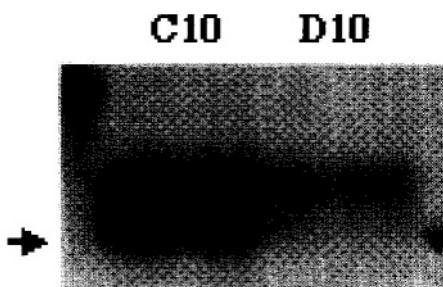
Expression of the FUS/CHOP fusion gene as determined by differential display of A375M melanoma. Cells were cultured in complete medium (C10) or in Tyr/Phe-deprived medium (D10) for 48 hr. The cells were harvested and total RNA was extracted with Trizol reagent (GIBCO-BRL, Grand Island, NY), according to the manufacturer's instruction. Three primers, (dT)12G, (dT)12C, and (dT)12A, were used to synthesize the first strand of cDNA with M-MLV reverse transcriptase (Promega, Madison, WI). The cDNA was used as a template to run PCR with arbitrary primers (Operon, Alameda, CA). [ $\alpha$ -<sup>33</sup>P]-dATP was used in the PCR reaction and the PCR products were fractionated on a urea-denatured 4.5% PAGE sequencing gel. The gel was dried in a Bio-Rad gel drier at 80 °C for 2 hr, exposed to X-ray film, and subsequently developed. The FUS/CHOP fusion gene band, indicated by the arrow in Figure 4, was cloned into the pGEM-T easy vector system (Promega). Specific sequences were
